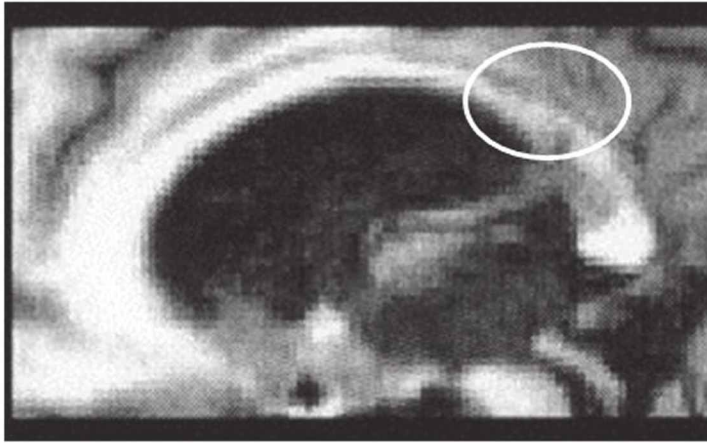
Performance on the CV syllables dichotic listening task in patients with circumscribed callosal lesions. Upper panel shows MR image of the corpus callosum in a patient (#P9) with a posterior callosal lesion. Lower panel show magnitude of the REA based on laterality index scores ($1.0 = 100\%$ REA, see formula on the y-axis title). The x-axis show the 10 patients (P1–P10) arranged from left to right according to whether their lesions were anterior (most leftward) or posterior (most rightward). Figure redrawn from data in Pollmann et al. (2002) with permission from the publisher.
